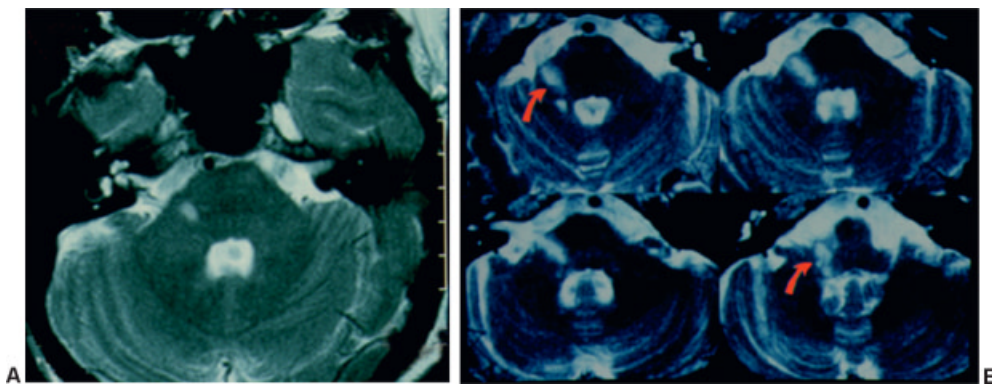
Fascicular and nuclear lesion of the vestibular nerve due to a multiple sclerosis (MS) plaque (A) and vascular lesion (B), mimicking vestibular neuritis (T2-weighted magnetic resonance images).
